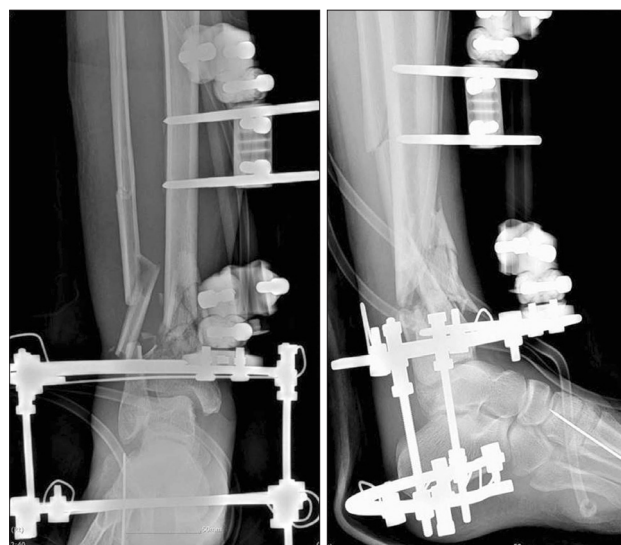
Radiographs showing acute shortening at defect site by external fixator after revascularization.
